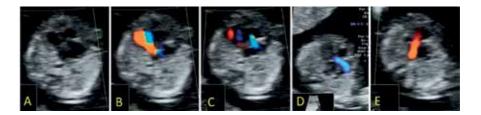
Hypoplastic right heart syndrome. Tricuspid atresia with intact septum. (A): Dysplastic thickened tricuspid valve in 4CV assessment, with lack of antegrade blood flow (B) and regurgitation (C). Normal aortic flow is visualized (D), and reversed ductal flow (E), by using color Doppler.
